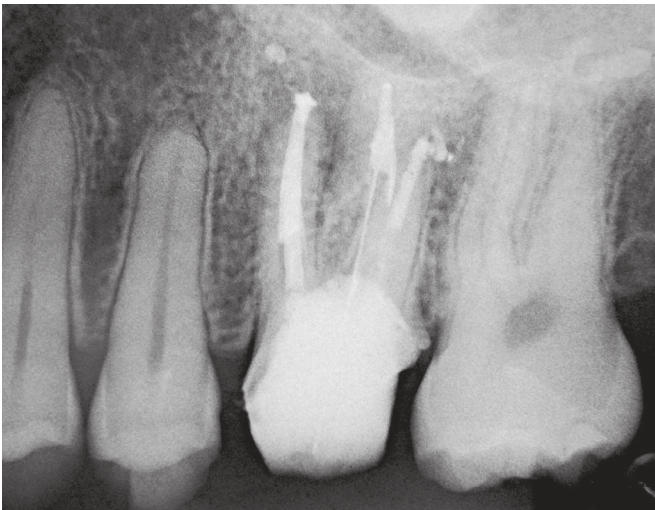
Final periapical radiograph. Note adequate endodontic treatment, satisfactory fiberglass post fitting and excellent crown sealing.
